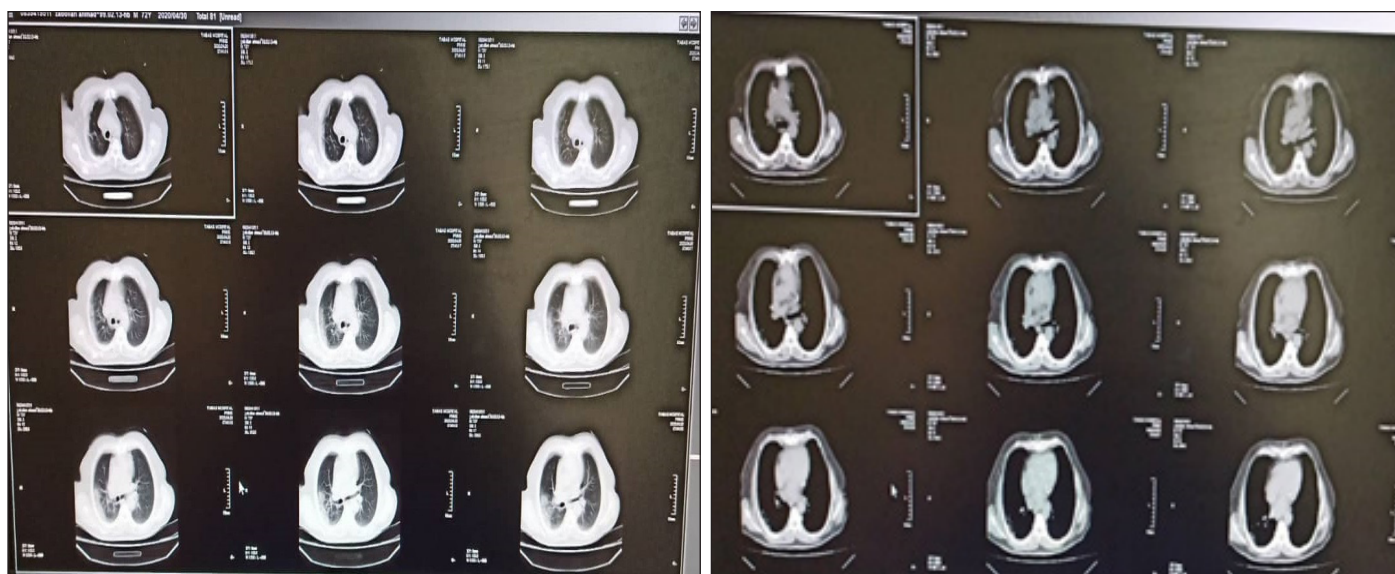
Chest CT shows multifocal peripheral consolidations in both lungs
